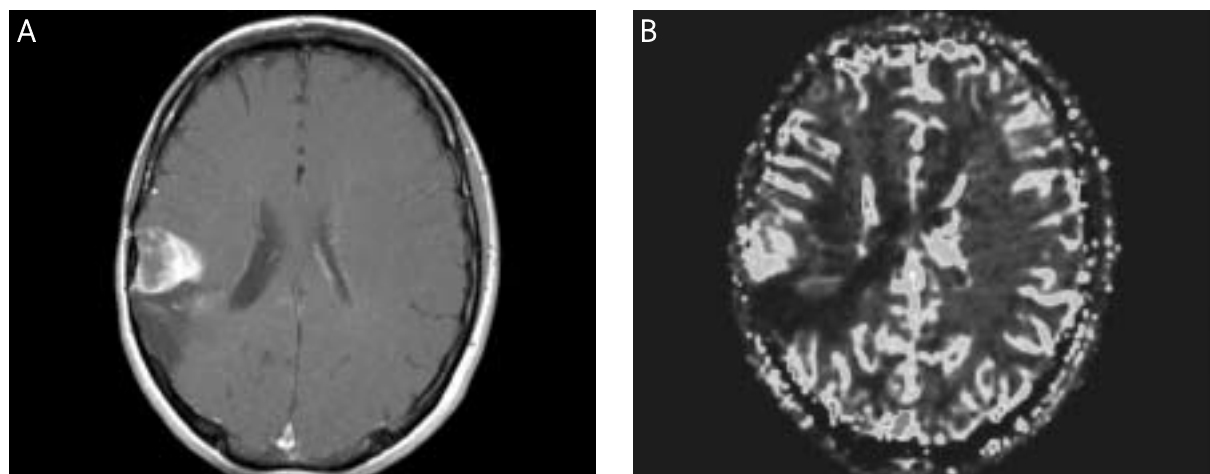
Recurrent Astrocytoma Anaplasticum WHO III. (A) Contrast-enhancing lesion VIII.11. CE T1-weighted imaging; (B) Contrast-enhancing lesion VIII.11. rCBV map.
